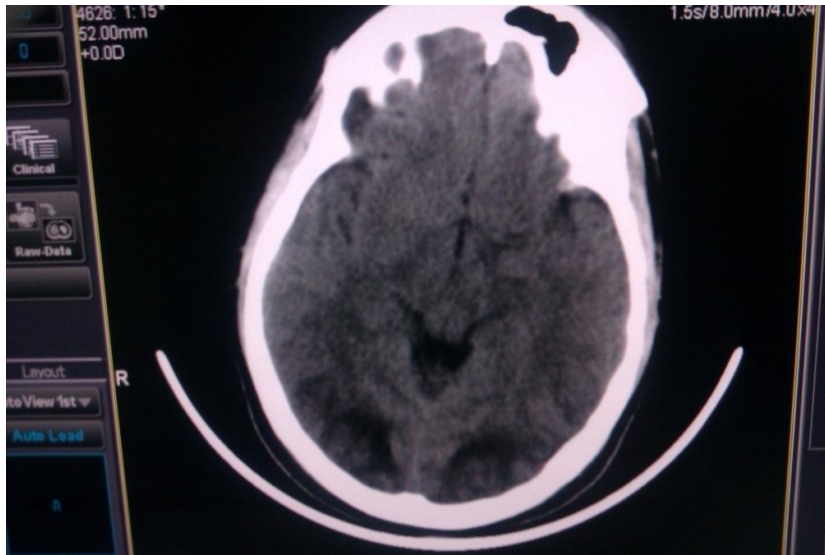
CT Brain showing symmetrical hypodensity in the bilateral occipital lobes in a case of PRES
